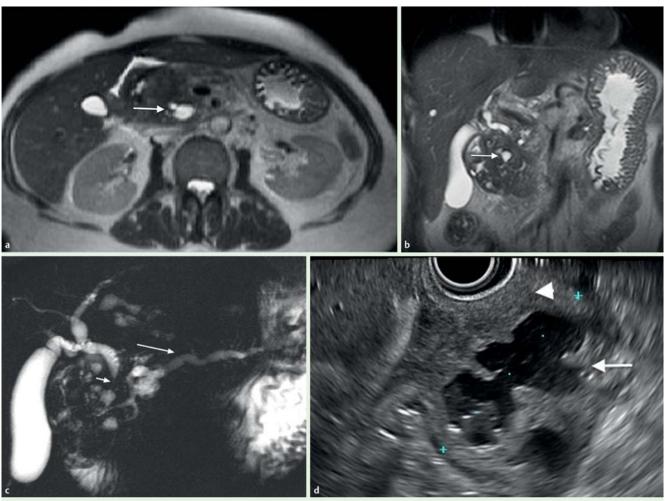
Periduodenal pancreatitis as shown on magnetic resonance cholangiopancreatography (MRCP) and endoscopic ultrasound (EUS). Axial (a) and coronal T2-weighted (b) images show thickening of the duodenal wall and of the groove with several cysts in the duodenal wall (arrow). c Coronal MRCP shows distal stricture of the common bile duct (short arrow) and of the main pancreatic duct associated with an upstream dilation (arrow). d EUS shows a hypoechogeneous heterogeneous lesion (arrow) located in the wall of the second portion of the duodenum, inside the muscularis propria, associated with a thickening of the duodenal wall (arrowhead).
